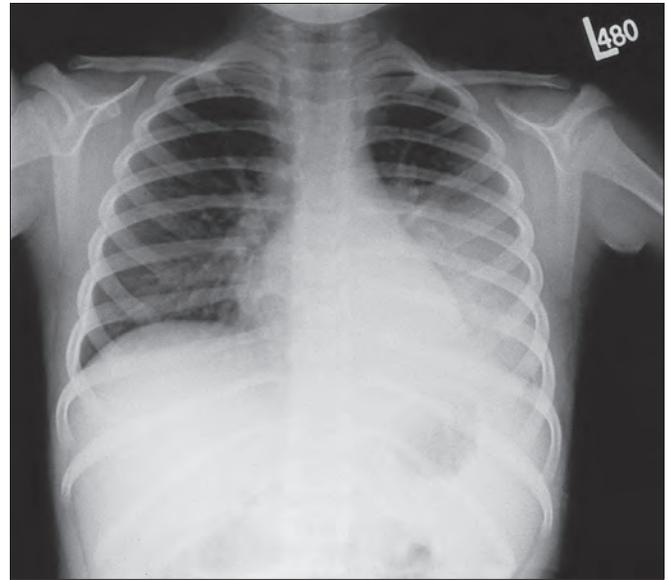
Left lower pneumonia. Burn patient with typical radiographic picture of lobar pneumonia. The diagnosis of pneumonia in patients with inhalation injury and respiratory distress syndrome is still arduous.
